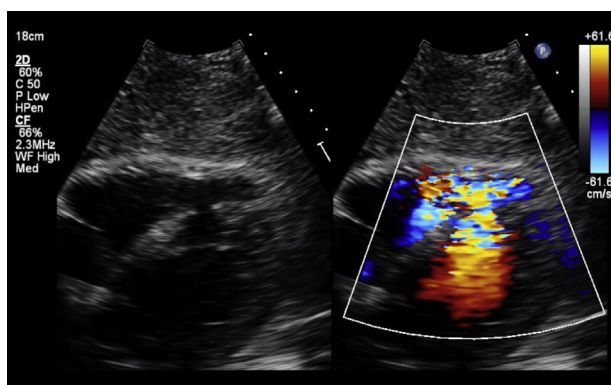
Subcostal view on TTE, without and with color Doppler (B), demonstrating a large VSD along the mid-to-apical portion of the septum, with left-to-right shunt.
